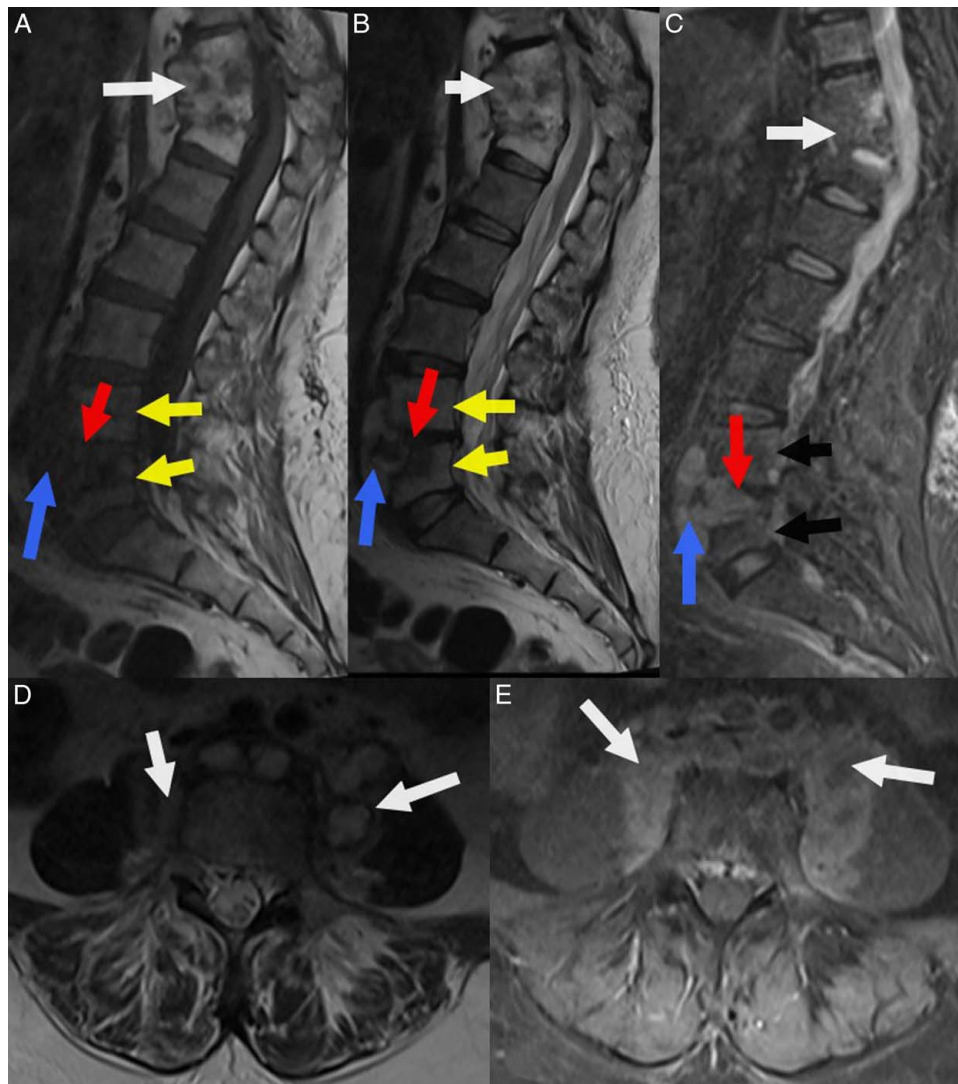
Follow-up spinal MRI in sagittal (A, B, C) and axial (D, E) plane performed 3 months after antibiotic therapy showing: – Sequelae of infectious treated thoracic spondylodiscitis with almost total fusion of D10, D11, and D12 responsible for thoracolumbar hinge angulation (A, B, C; white arrows). – Irregularities and subchondral erosions of the lower vertebral endplate of L4 and upper L5 with signal abnormalities of L4 and L5 vertebral body in hyposignal on T1-weighted image (A; yellow arrows) and hypersignal on T2-weighted image (B; yellow arrows) and moderate enhancement after Gadolinium injection (C, black arrow). – Intradiscal abscess (A, B, C; red arrows). – Anterior L4 and L5 epiduritis (A, B, C; blue arrows) coming into contact with both L5 roots and infiltration of the anterior and lateral paravertebral soft parts causing small collections of both iliopsoas muscles (D, E; white arrows).
